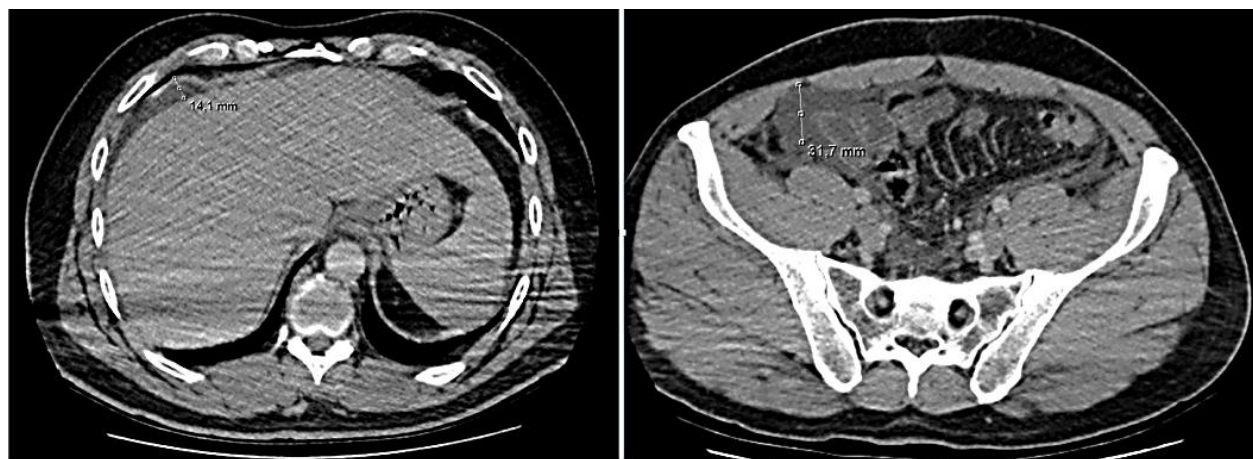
Contrast-enhanced abdominal computed tomography image of the patient.
